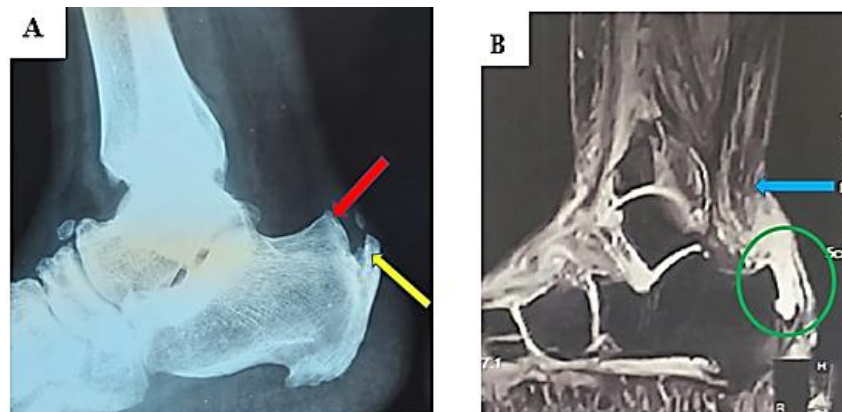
A: preoperative X-ray shows insertional calcific AT tendinitis (yellow arrow) with Haglund deformity (red arrow). B: MRI shows insertional AT rupture (green circle) with retracted proximal stump (blue arrow)
